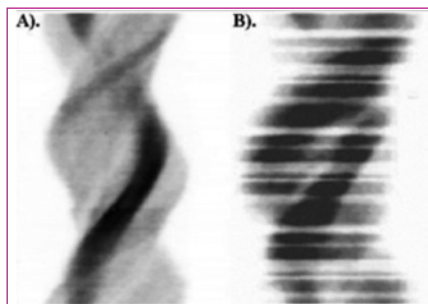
A, B: Comparison of a normal myocardial perfusion SPECT sinogram (A) and the striped appearance characteristic of count losses resulting from inadequate gating of the SPECT data (B). (From Wheat and Currie [6])
